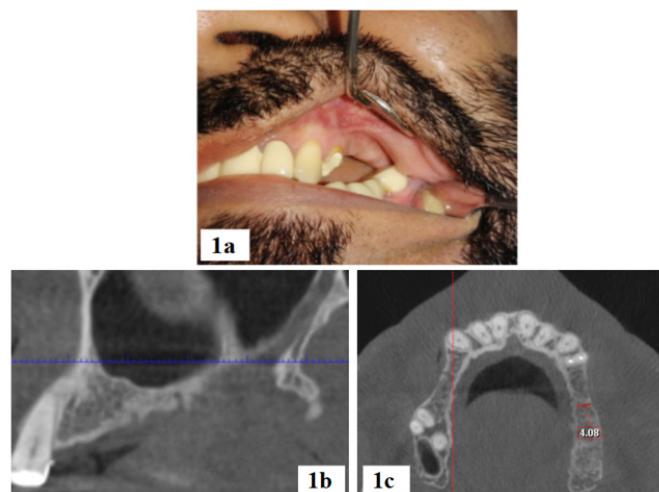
1a. Preoperative intraoperative clinical image showing the edentulous site with ridge atrophy. 1b. CBCT sagittal view indicating the reduced vertical bone height. 1c. Preoperative CBCT axial view demonstrating the horizontal bone deficiency, showing the thickness of the bone 4.08 mm buccolingually.
